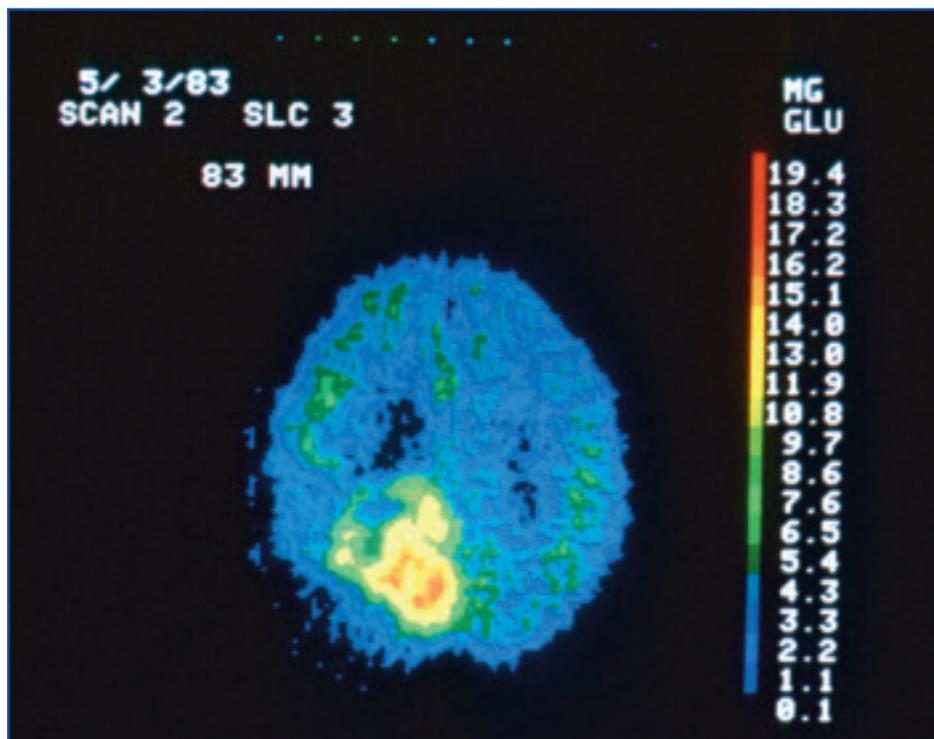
Brain tumor: Shown is a PET scan image of a patient diagnosed with a brain tumor (astrocytoma). The patient was injected with a radioactive tracer, fluorodeoxyglucose (FDG). FDG is an analog of glucose that is readily taken up by cells, as if it were glucose. Because it has a slightly different chemical structure than glucose, FDG cannot be broken down by the cells of the body and accumulates. The cells that accumulate the radioactive tracer the fastest, such as cancer cells, light up the most on a PET scan image. As a result of its increased uptake of the radioactive tracer, the tumor appears as the bright orange and yellow area on the lower left side of the brain. *Source: Dr. Giovanni De Chiro, National Institute of Neurological Disorders and Stroke.*
